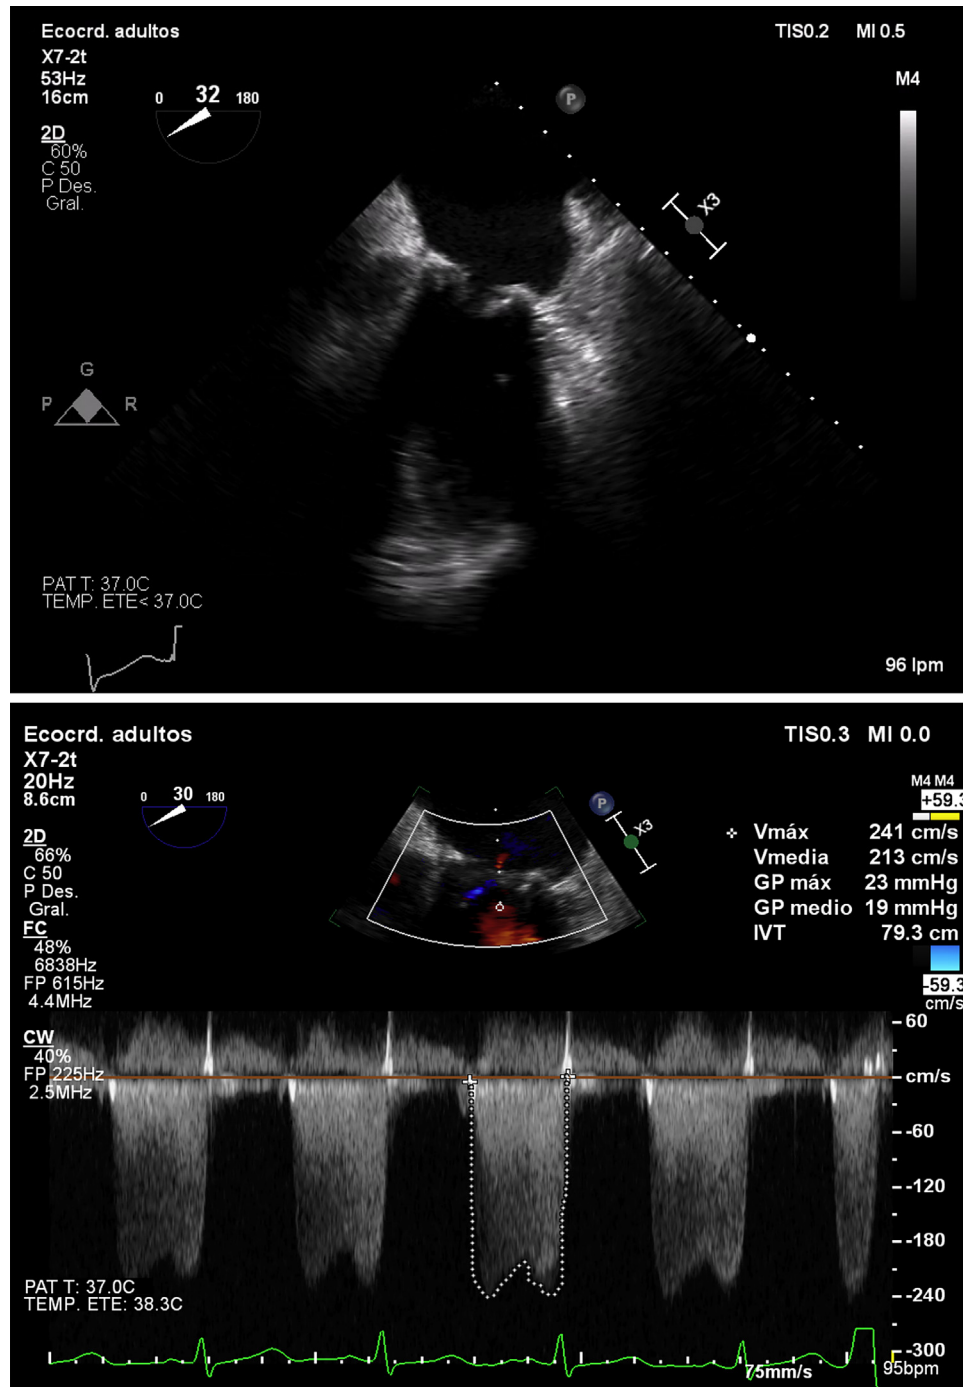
Transesophageal echocardiography (2-dimensional) on admission: mesoesophageal 2-chamber view showing thickened leaflets compatible with laminar thrombus with limited mitral valve opening (transmitral gradient of 19 mm Hg).
